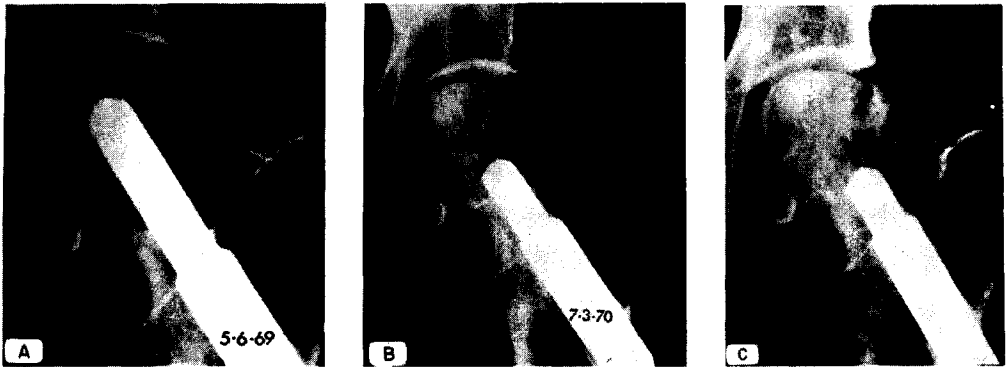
A, Fracture of femoral neck. Radiograph on completion of pinning and within 6 days of fracture. Bone structure of femoral head is indistinguishable from surrounding bone but it is, in fact, necrotic (see B).
